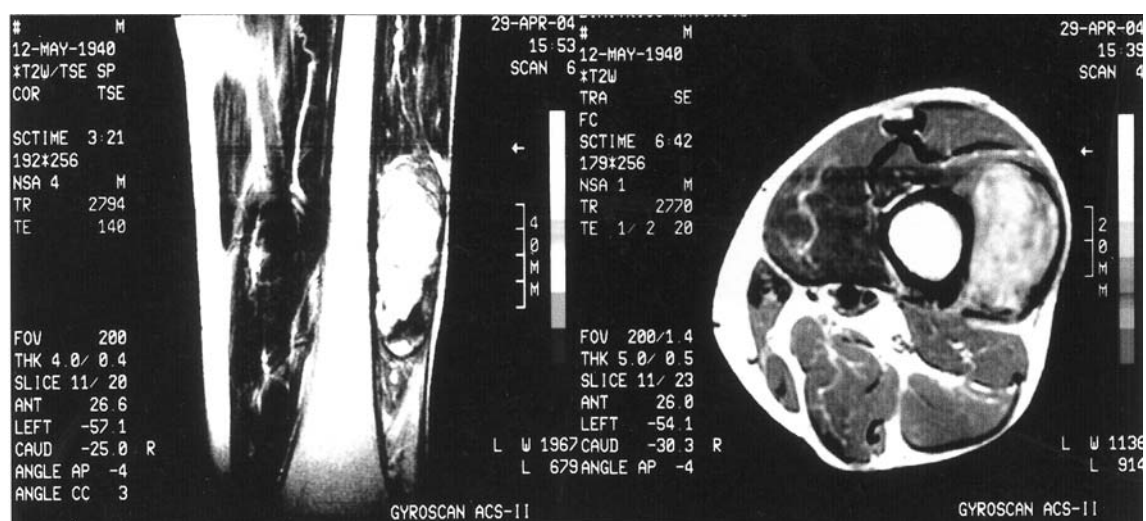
MRI scan revealed a 5.5x3.5x3.5cm lobulated, heterogeneous, contrast-enhancing soft-tissue mass involving the lateral head of the quadriceps muscle with nodular areas of increased density.
